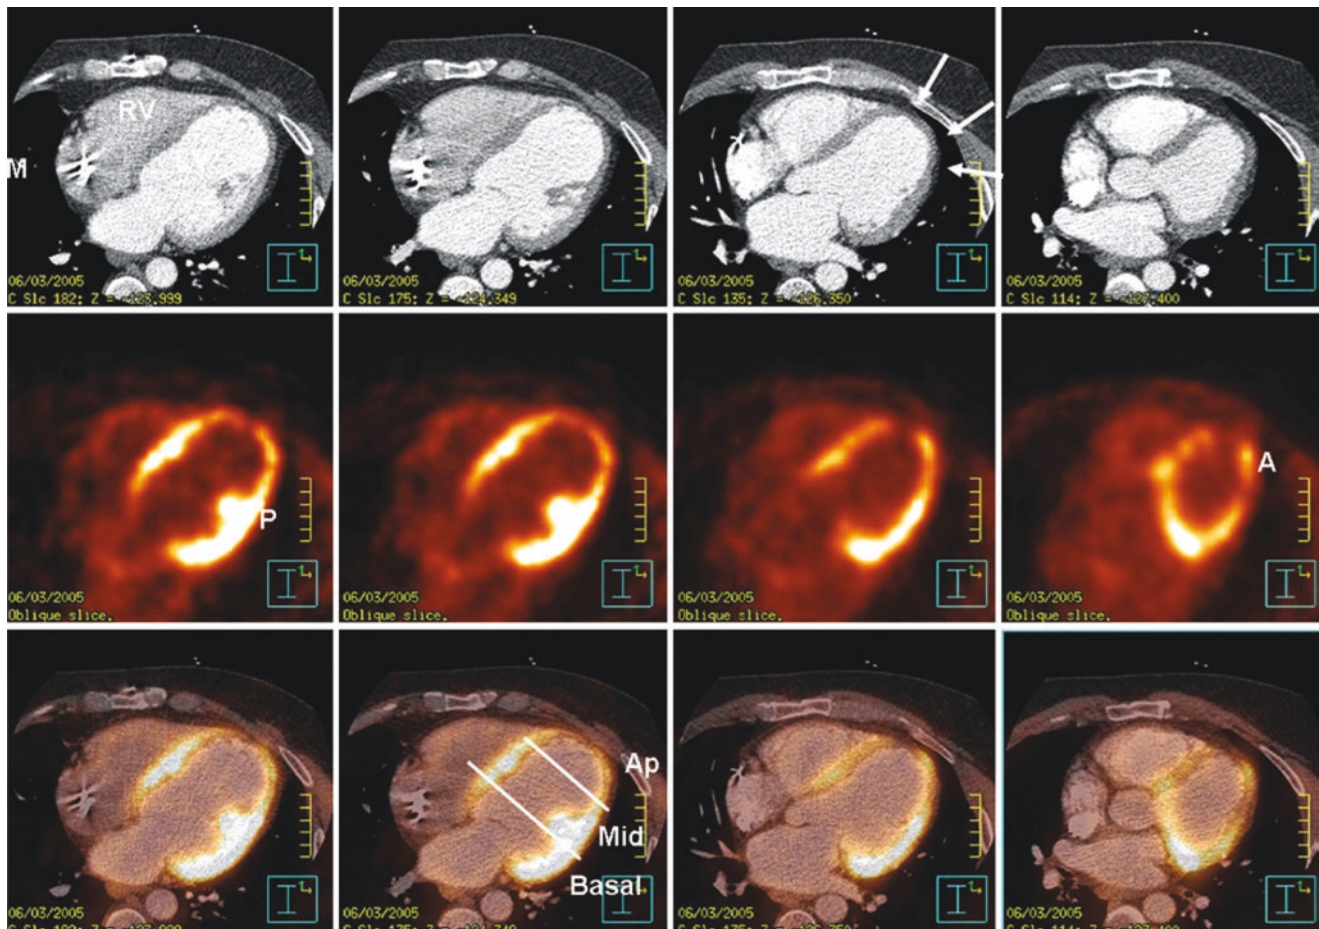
A fusion of PET FDG and CT images for use in PET-guided ventricular tachycardia ablation therapy. *Top row:* Contrast-enhanced CT demonstrates all cardiac chambers, including the right ventricle (RV), left ventricle (LV), and a metal artifact (M) of an implantable cardioverter defibrillator lead in the right atrium. Significant wall thinning (arrows) is noted in the apical and lateral LV walls, which is consistent with myocardial infarction. *Middle row:* A matching decrease in signal intensity in apical and lateral wall segments is observed in PET
